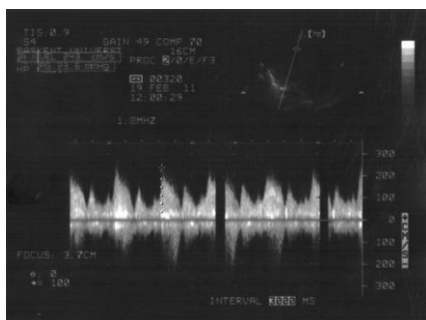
Continuous wave doppler recordings from the parasternal position of an infarct related ventricular septal defect. The peak systolic velocity is 2.4 cm/s, corresponding to a 24 mmHg pressure gradient between the LV and RV. Systolic blood pressure was 100 mmHg; hence, RV systolic pressure=100-24=76 mmHg. There is a continuous shunt through the VSD except during early diastole. LV, left ventricle, RV, right ventricle, VSD, ventricular septal defect.
